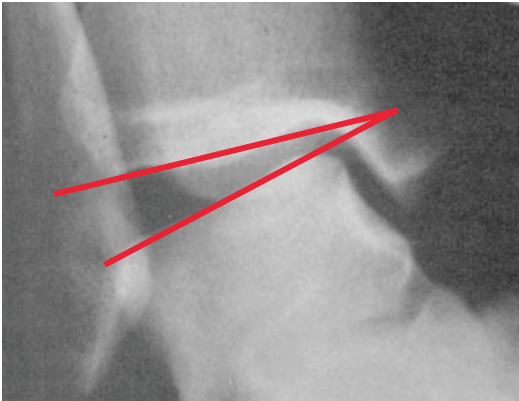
Stress radiograph of the ankle. Anteroposterior X-ray of the ankle in which the examiner puts counter pressure on the lower leg with one hand and inverts the foot with the other hand. This can be carried out on both the injured and uninjured side. The angle between the tibia and talus is measured on both sides (*talar tilt*). If the difference on the injured and on the uninjured side is less than 5° this is within the normal physiological situation. If the difference is between 5° and 10° there is a possible insufficient lateral ankle ligament complex and in more than 10° then there is strong evidence of an insufficient lateral ankle ligament complex
